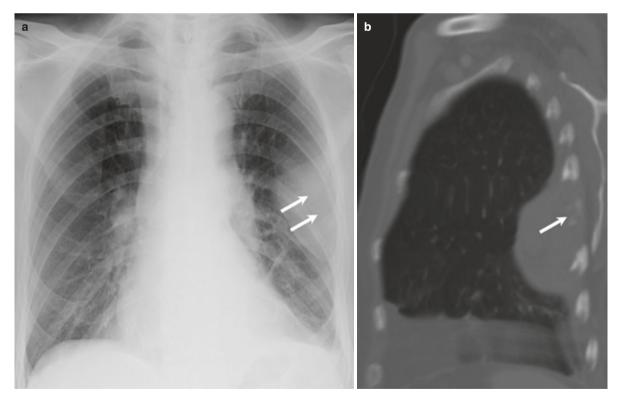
A 69-year-old man with bronchial carcinoma invading the chest wall. (a) Frontal radiograph of chest shows a soft tissue mass projected over left mid zone with associated rib destruction (arrows).
